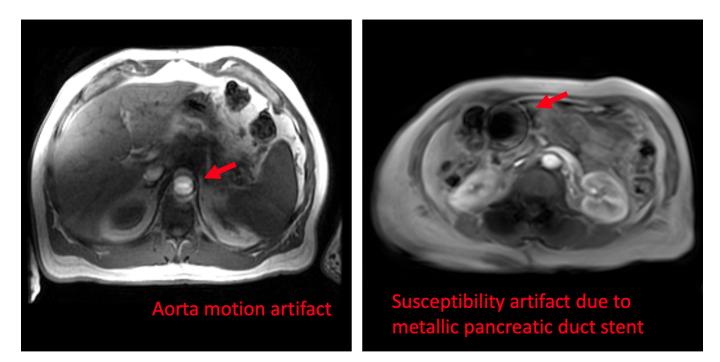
Example images for in-volume motion and susceptibility artefacts in MRI images. Left: a
